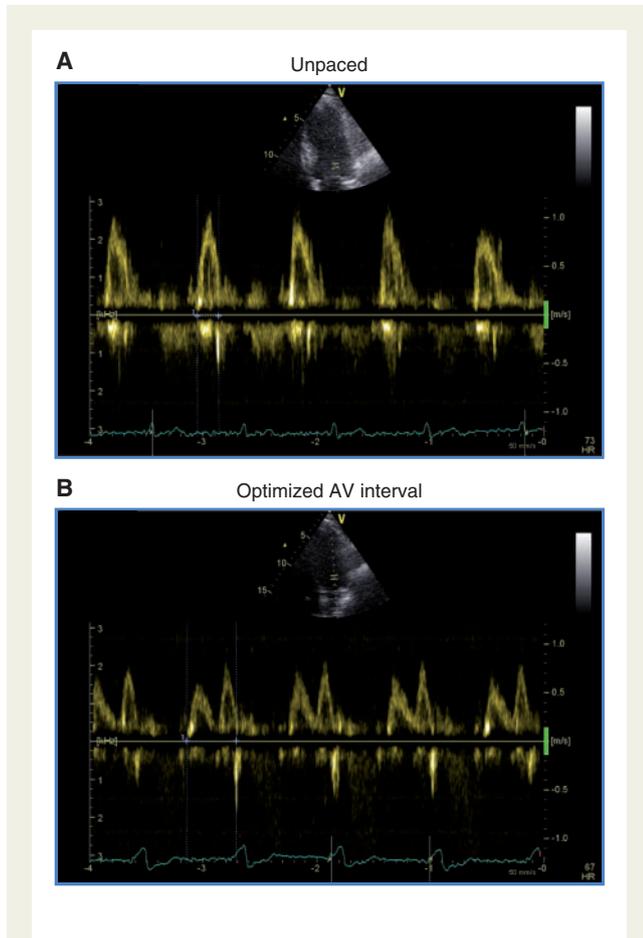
Echocardiographic images of (A) a patient with a PR interval of 380 ms without pacing and (B) restoration of AV coupling by optimized atrial sensed ventricular pacing (140 ms after atrial sense). (Unpublished by Stockburger). AV, atrioventricular.
